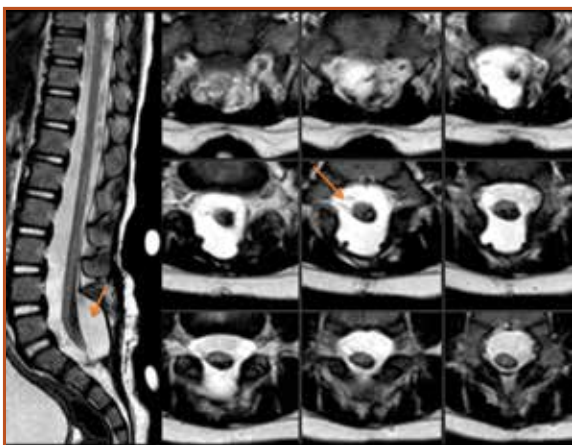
Post-operative T2 weighted MRI images of the patient in Figure 5 showing the untethered spinal cord circumferentially surrounded by cerebrospinal fluid. Arrow: Cerebrospinal fluid. (Personal collection)
